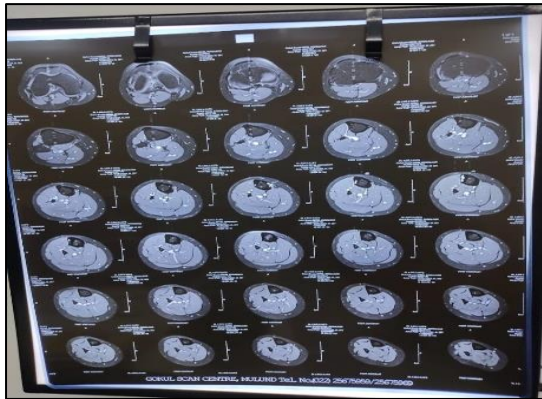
CT scan of proximal tibia.
